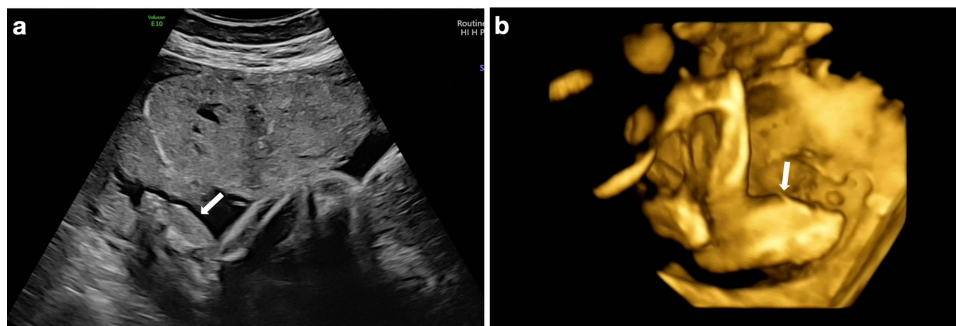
Prenatal ultrasonographic images of the fetus. (a) Two-dimensional ultrasound revealed the dorsal foot edema of the fetus. (b) Three-dimensional ultrasonographic image.
